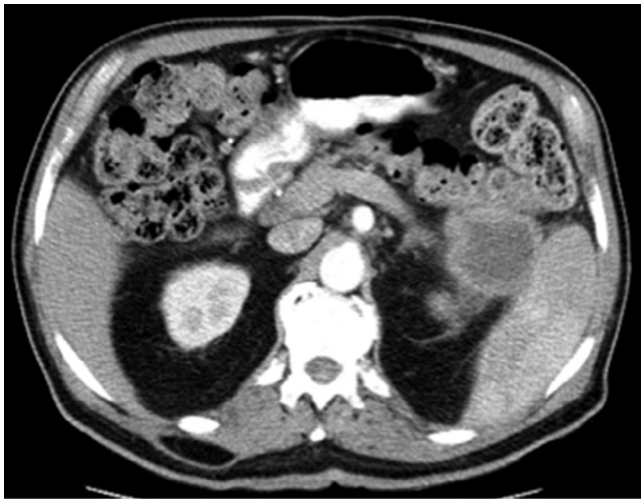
Axial and sagittal projections of the patient’s contrast-enhanced computed tomography of the abdomen demonstrate an approximately $7 \times 8 \times 7$ cm mass with central hypodensity arising from the tail of the pancreas. Fat planes between the mass and the stomach, the transverse colon, the spleen, and the left kidney are completely effaced. There is thickening of the walls of the stomach and the transverse colon immediately adjacent to the pancreatic mass.
